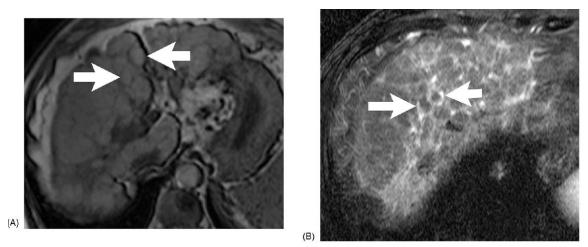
Cirrhosis and multiple regenerative nodules at MR imaging. Transverse T1weighted gradient-echo MR image (A) shows multiple subcentimeter isointense nodules (arrows), surrounded by diffuse lacework of low-intensity fibrosis. On transverse T2weighted fat-suppressed turbo spin-echo MR image (B), nodules (arrows) are still isointense and surrounded by thick hyperintense septa of lacelike fibrosis. Arterial dominant phase (not shown) failed to show enhancement of nodules, consistent with diagnosis of regenerative nodules.[17]
